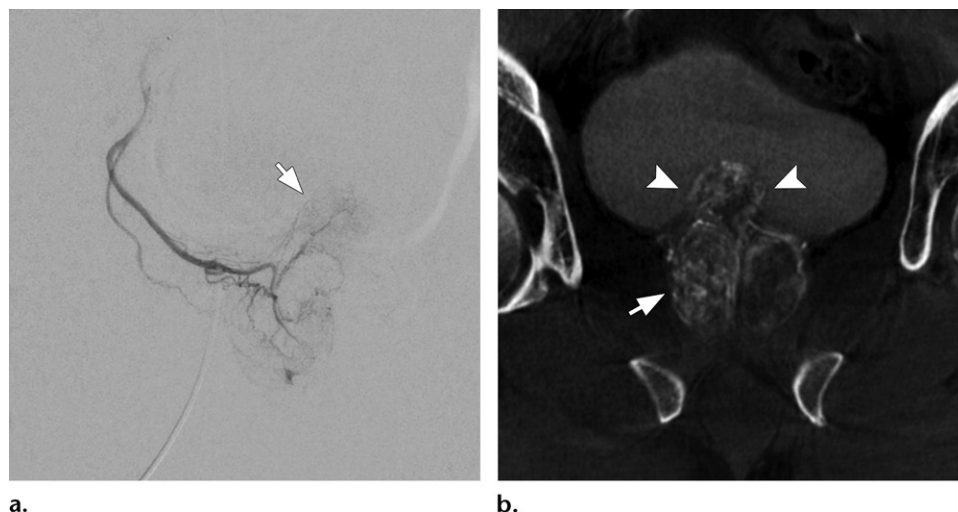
Cone-beam CT after selection of the right PA. (a) Right PA arteriogram shows prostate blush extending medially toward the bladder base (arrow). (b) Coronal cone-beam CT of the right PA confirms perfusion to the prostate (arrow), including the median lobe (arrowheads).
